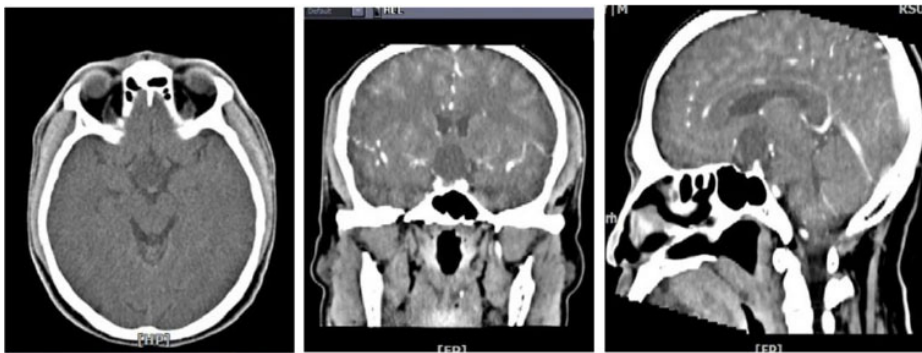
Hypodense lesion with fluid density in the sellar region compressing the optic chiasm, shown on CT Scan Examination, suggests a benign sellar subarachnoid cyst.
